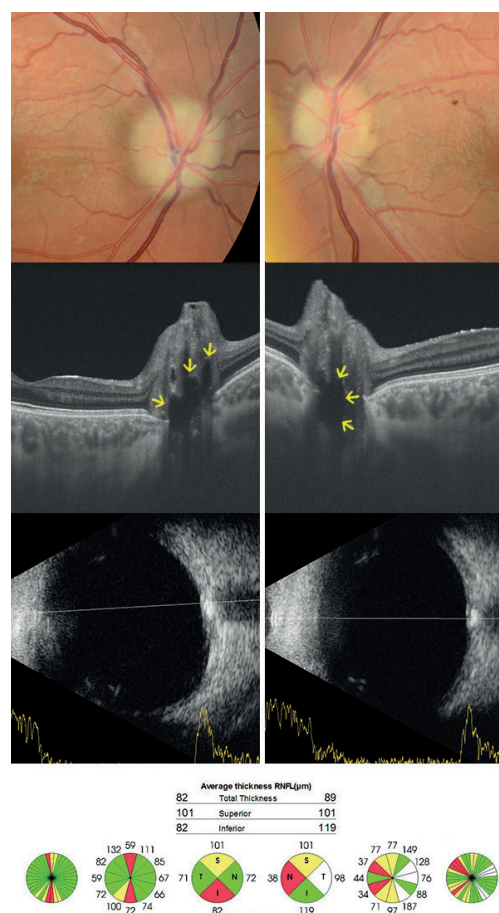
Bilateral fundus photography of the oldest patient in our study group shows pseudopapilloedema and subtle pallor of optic disc. There are multiple hyporeflective lesions in linear horizontal transpapillary swept source OCT scans corresponding to optic disc drusen. Optic disc drusen are highly reflective on ultrasound B-scan. Average thickness of the peripapillary retinal nerve fibre layer (pRNFL) is reduced
